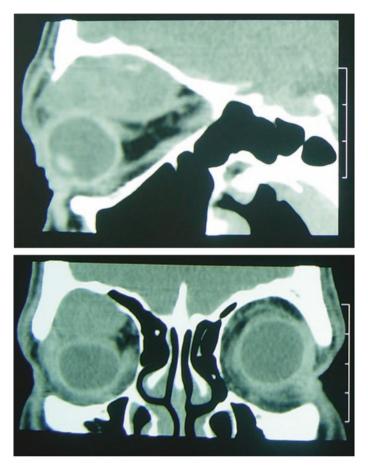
a Large mass is found in superior of orbit that seems to be extraconal. Superior rectus muscle and levator muscle are visible and the tumor seems to be subperiosteal. b Coronal view of CT-scan that reveals excavation in the orbital roof
